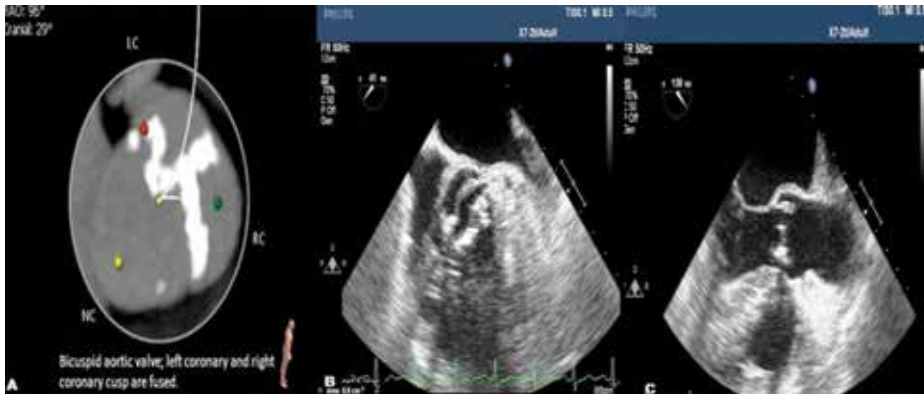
(A) Computed tomography is showing the bicuspid aortic valve and the fusion of left coronary and right coronary cusps, (B) Trans-oesophageal echocardiography demonstrates the bicuspid aortic valve in the short axis, (C) Trans-oesophageal echocardiography demonstrates the bicuspid aortic valve in the long axis.
